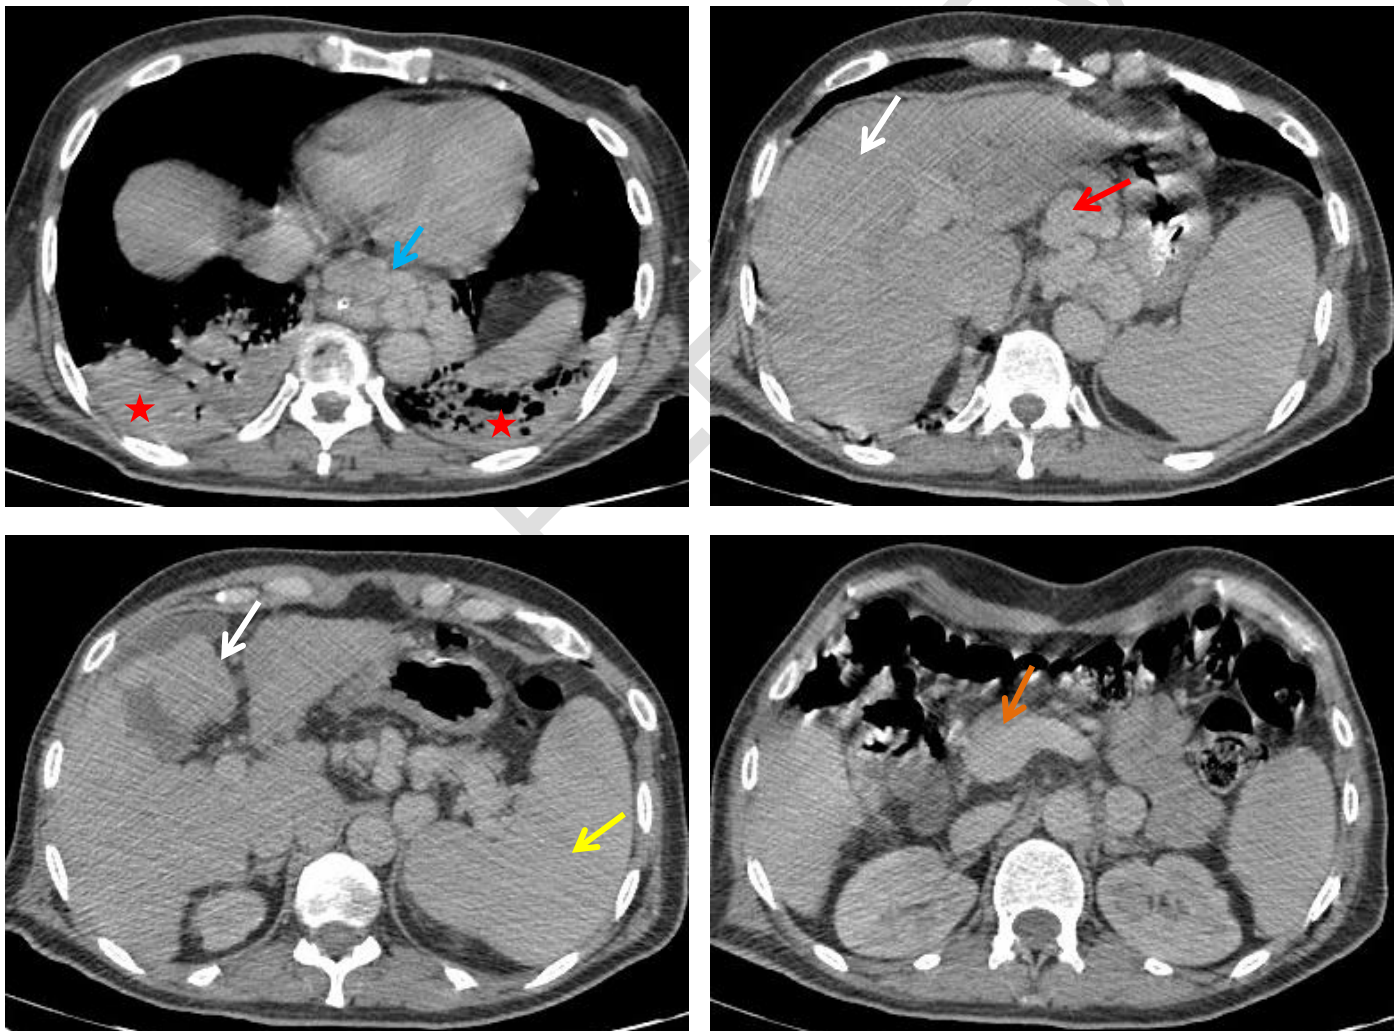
Abdominal CT showing signs of chronic hepatopathy (white arrows), paraesophageal varices (blue arrow), gastroduodenal shunt (red arrow), enlarged superior mesenteric vein (orange arrow) and splenomegaly (yellow arrow). Note bilateral lung consolidation in favour of aspiration pneumonia (red stars).
